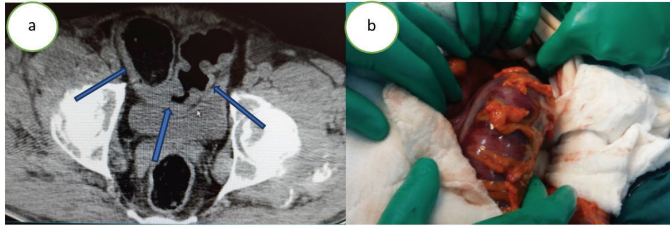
(a) Segmental wall thickness at the sigmoid colon on computed tomography; (b) Intra-operative view of the colon
